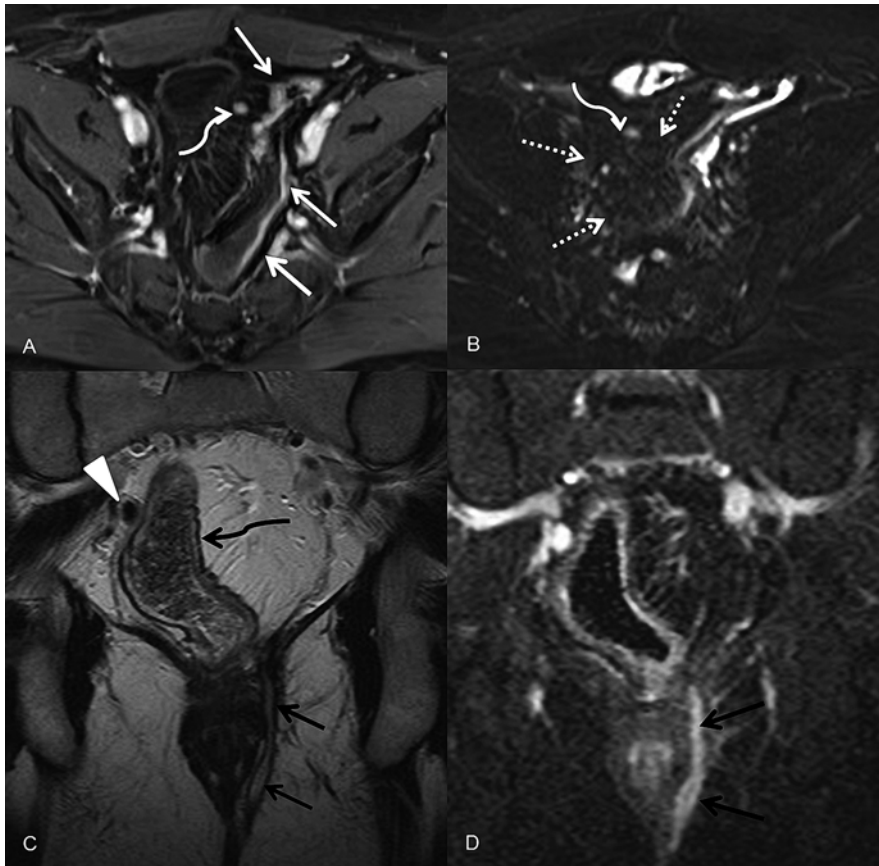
Axial T1, contrast-enhanced MR image with fat suppression (a) in a patient with IPAA and symptomatic pouchitis shows thickening of the pouch wall with increased enhancement (*white arrows*). An enlarged lymph node is also present (*curved arrow*). Axial T2-weighted image with fat suppression (b) shows mild inflammatory stranding adjacent to the pouch (*dashed white arrows*). Enlarged lymph node is also seen (*curved arrow*). Coronal T2-weighted MR (c) image from a different patient with IPAA complications. Similar to the prior case, the pouch wall is thickened (*curved black arrows*), and there is a prominent lymph node adjacent to the pouch (*white arrowhead*). A T2 hyperintense intersphincteric fistula extends from the IPAA to the perineal subcutaneous tissues (*black arrows*). Coronal contrast-enhanced subtracted T1-weighted MR image (d) at the same level shows peripheral enhancement of the fistula (*black arrows*)
